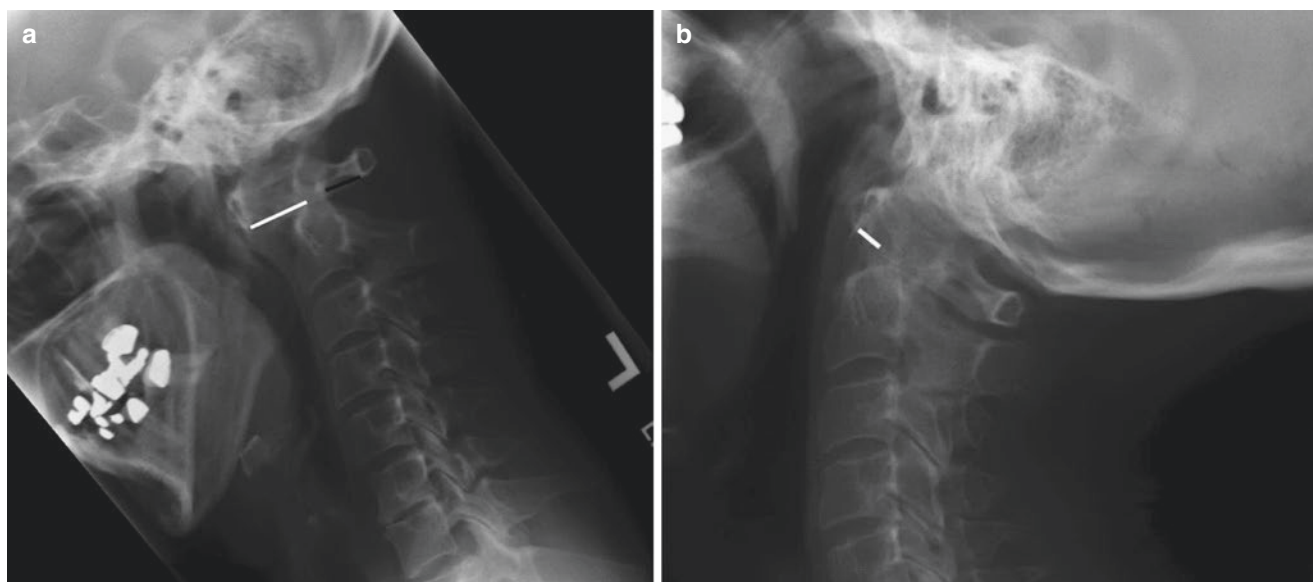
Lateral X-ray of cervical spine in (a) flexion showing anterior atlanto-dens interval (AADI) of 17 mm (white line) and posterior atlanto-dens interval (PADI) of 11 mm (black line) and (b) reduction of AADI (white line) of 6 mm in extension
